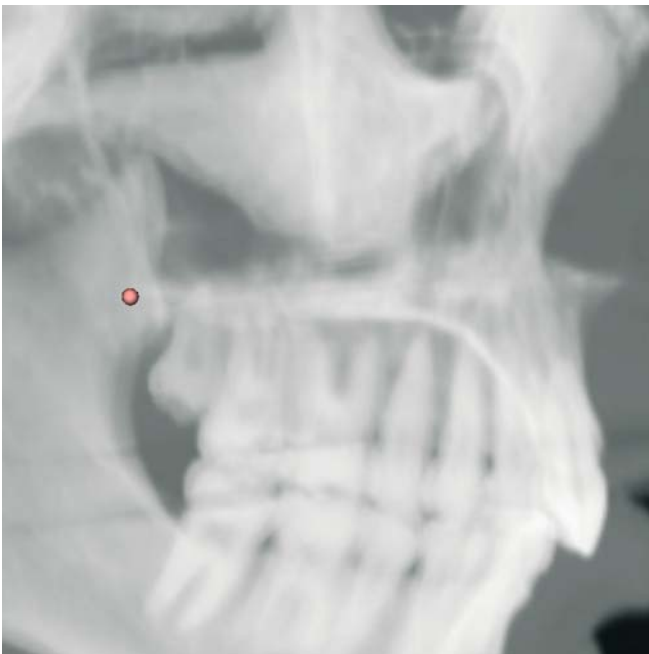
Posterior Nasal Spine. Virtual lateral cephalogram (3-D CT, patient K.C.)
